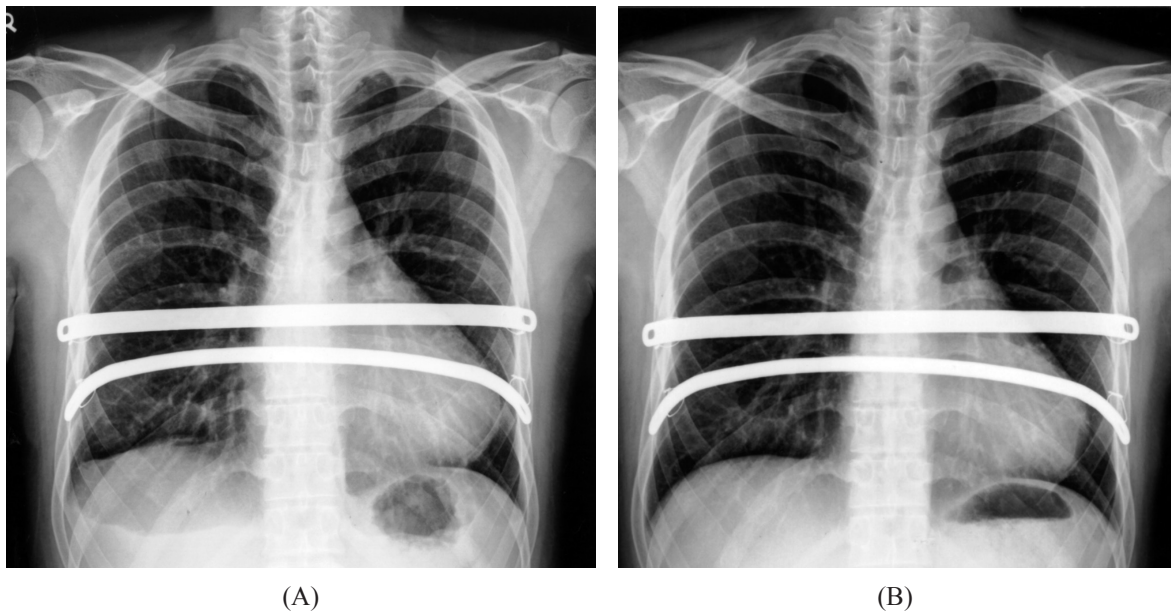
(A) Chest radiograph on the 7th day after subxiphoid pericardiotomy revealing normal cardiac size. (B) Chest radiograph obtained in the outpatient department 4 weeks after subxiphoid pericardiotomy, showing improvement.
